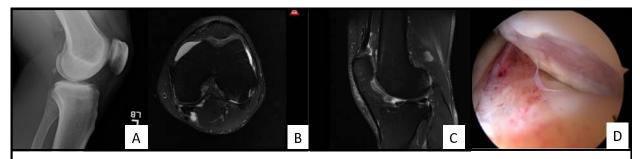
Representative imaging of patient 7. Chronic left lateral knee pain in the setting of fabella syndrome. Bony fabella identified on preoperative radiographs (A). A notable cartilage lesion was identified on both axial and sagittal T2 MRI on the posterior lateral femoral condyle (B and C). Arthroscopic view from the posterior lateral portal of the chondral defect caused by the fabella impaction (D).
